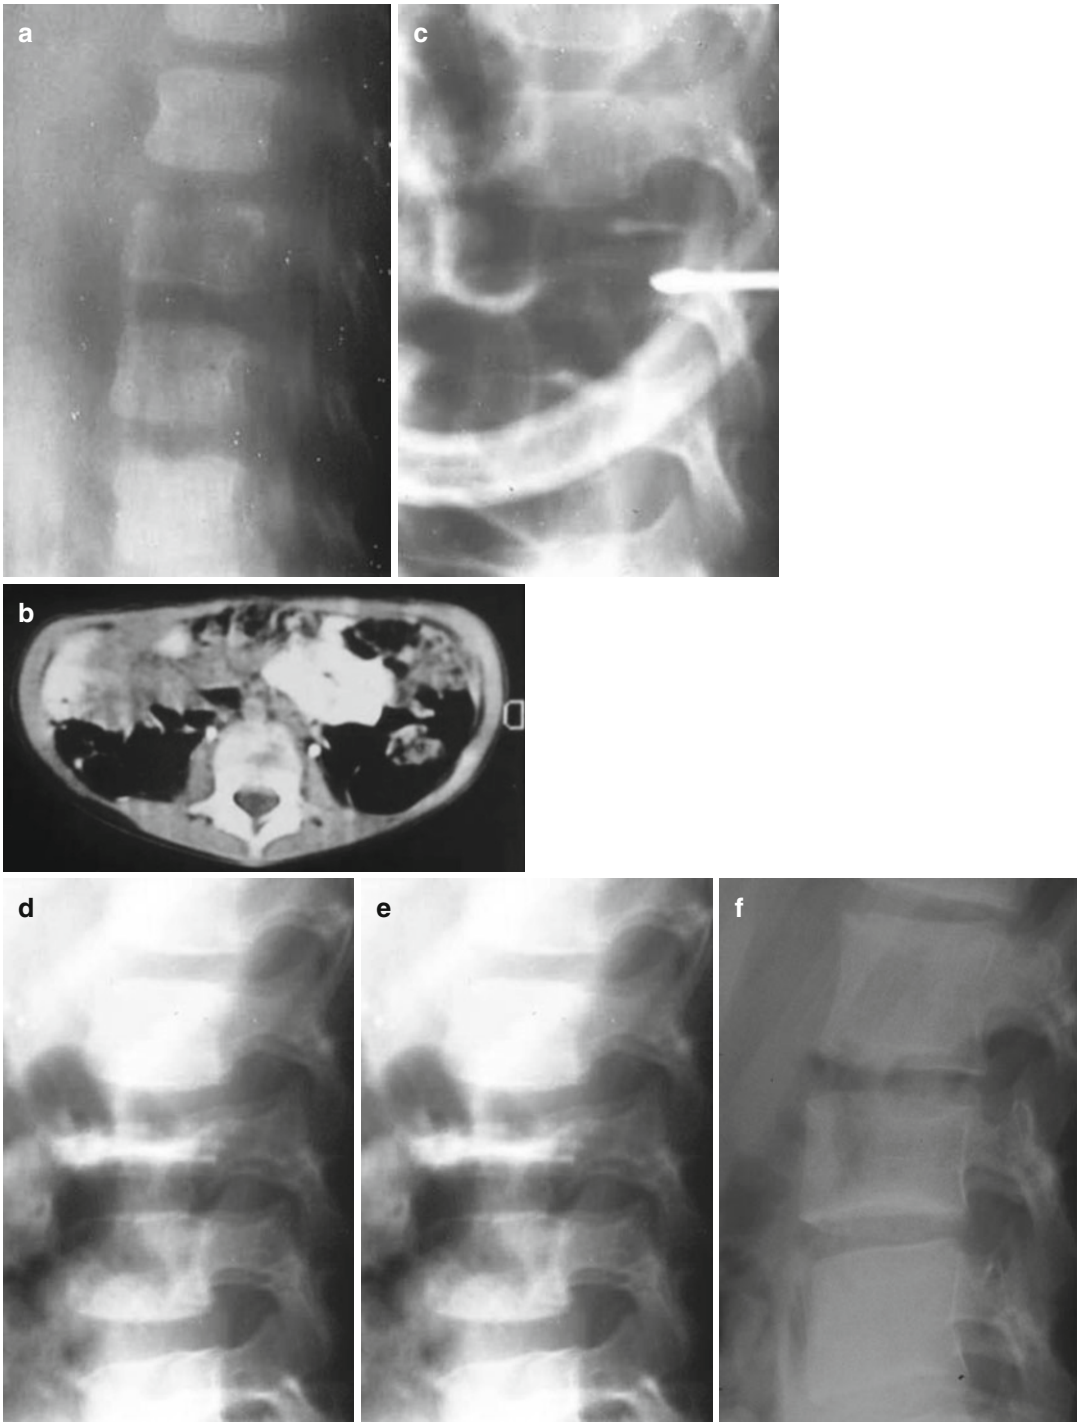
A 4-year-old male, back pain and muscle spasm. Case observed in 1992 (a, b) Sagittal Tomography and CT scan show initial lytic changes in L2 vertebral body. (c) Biopsy was performed by transpedicular open approach and allowed the diagnosis of Eosinophilic granuloma. (d)
